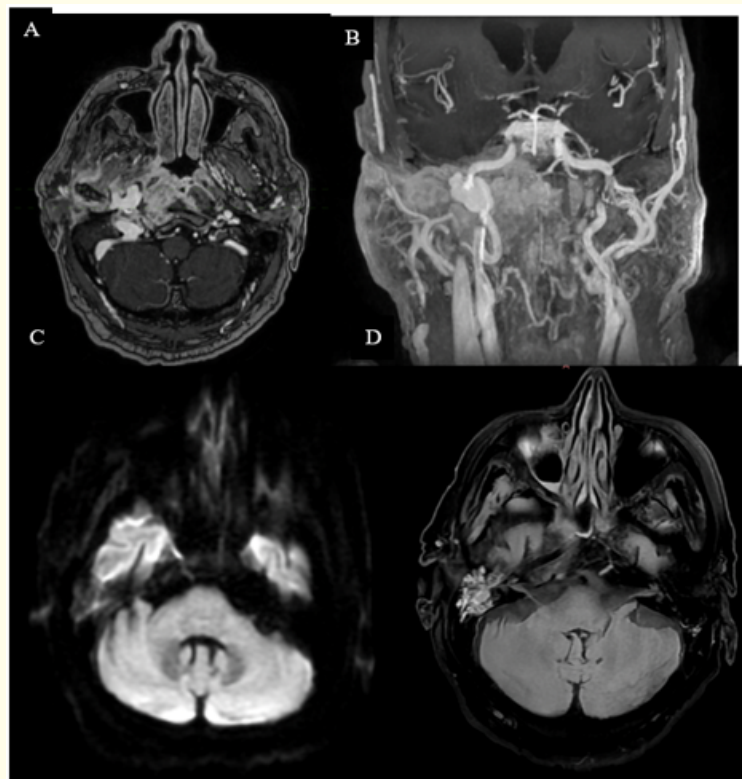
MRI characterization of the aneurysm and middle ear cholesteatoma.
